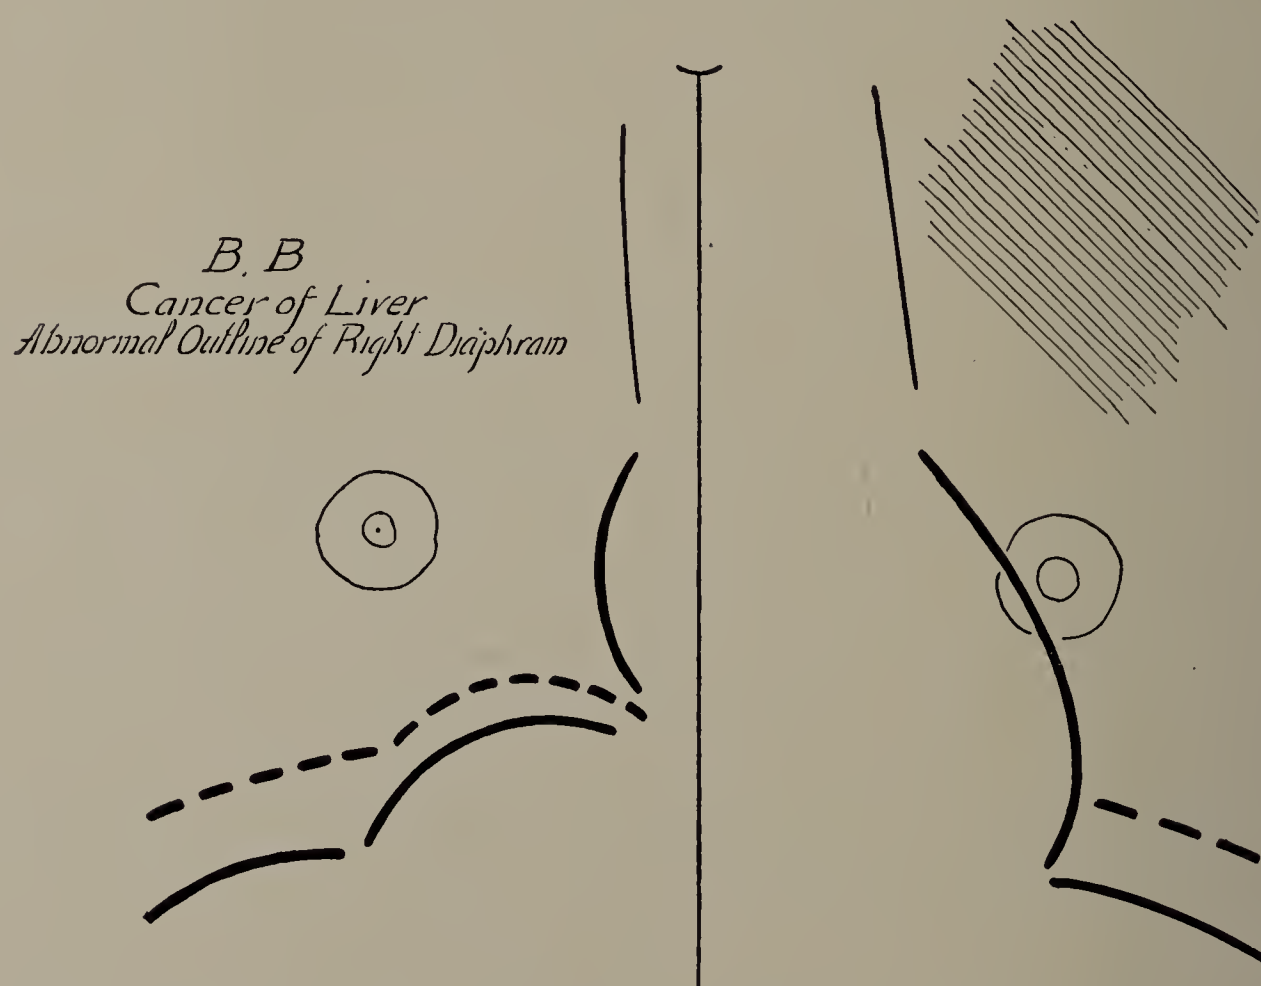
B. B. Cancer of liver. Cut of X-ray tracing. Auscultation and percussion indicated to the physician of the patient extension of the disease into the thoracic cavity. My X-ray examination showed no evidence of this extension. Broken line and full line below it show abnormal outline of diaphragm in expiration and inspiration respectively. (Cut one-third life size.)
